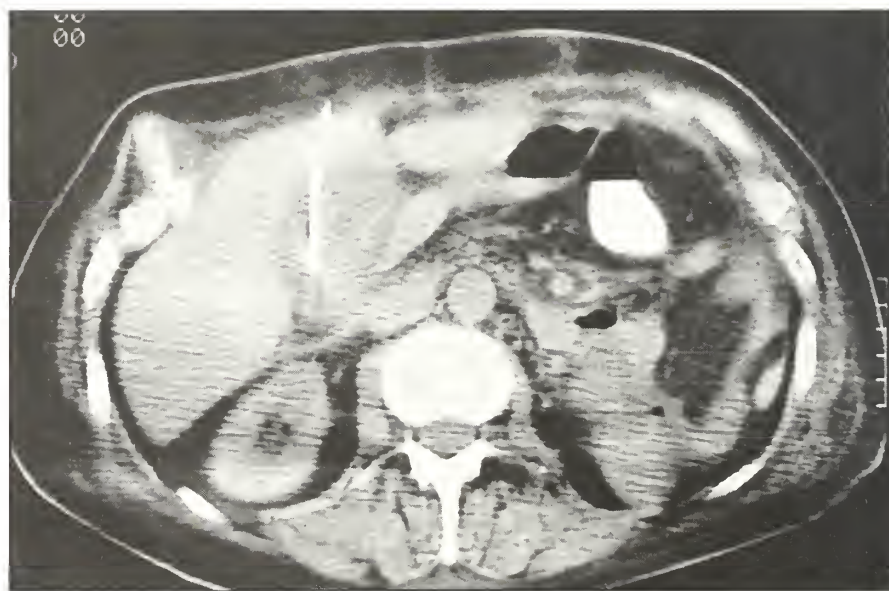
Computed tomographic monitoring of percutaneous cholecystostomy. The catheter is visualized coiled within the gallbladder.
